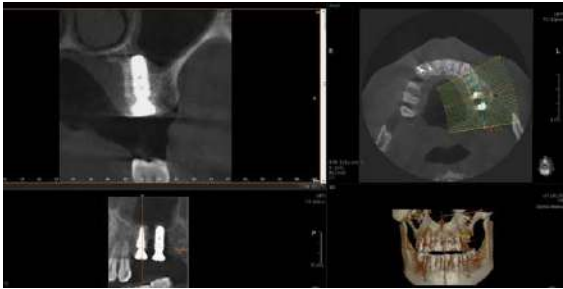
Post-op CT. #26 (upper), #27(lower)
